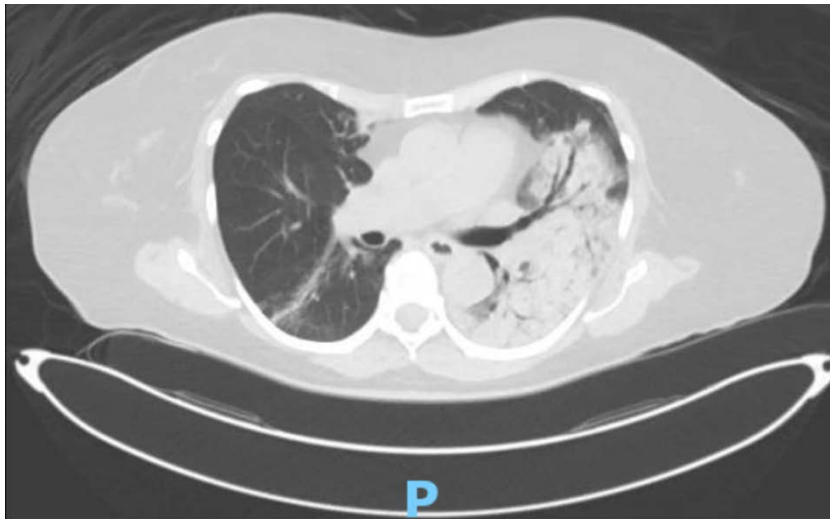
Computer tomography (CT) of the chest without IV contrast on initial presentation
